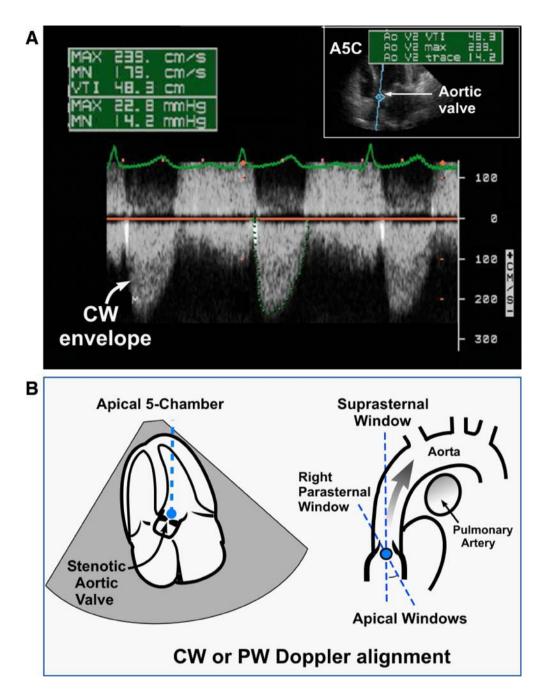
(A) Continuous-wave (CW) Doppler of maximum velocity across stenotic aortic valve. (B) Optimal Doppler alignment for assessment of peak velocities in aortic stenosis.
